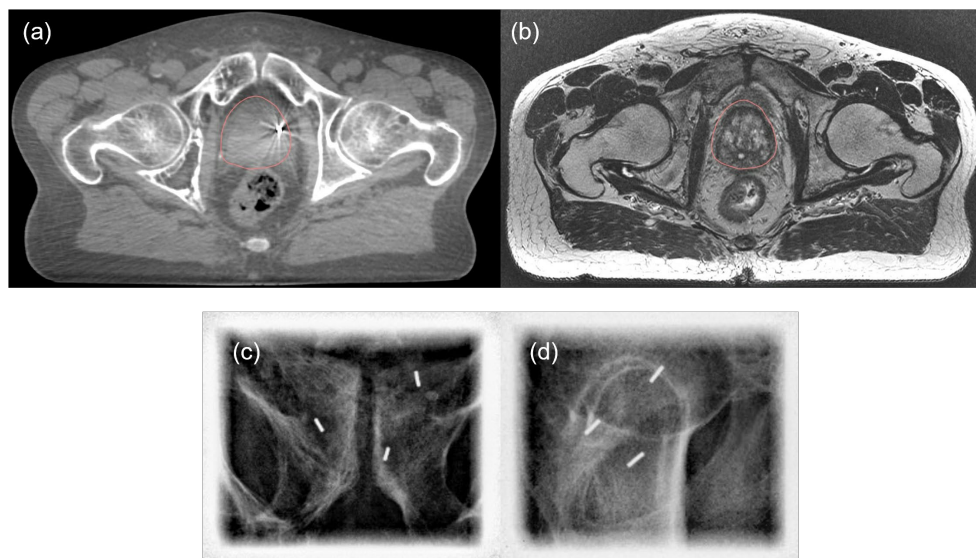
A CBCT (a), MRI (b), frontal planar kV X-ray (c) and side planar kV X-ray (d) of a prostate cancer patient. The prostate is delineated in pink in the CBCT and MRI. The soft tissue contrast can be compared between the images. Different soft tissue structures are distinguishable in the CBCT, but the MRI has the superior soft tissue contrast. Only bony anatomy and the fiducials are visible in the X-rays. One gold fiducial marker in the prostate is visible in the CBCT with some artefacts surrounding it. That fiducial marker can however not be seen in the MRI.
